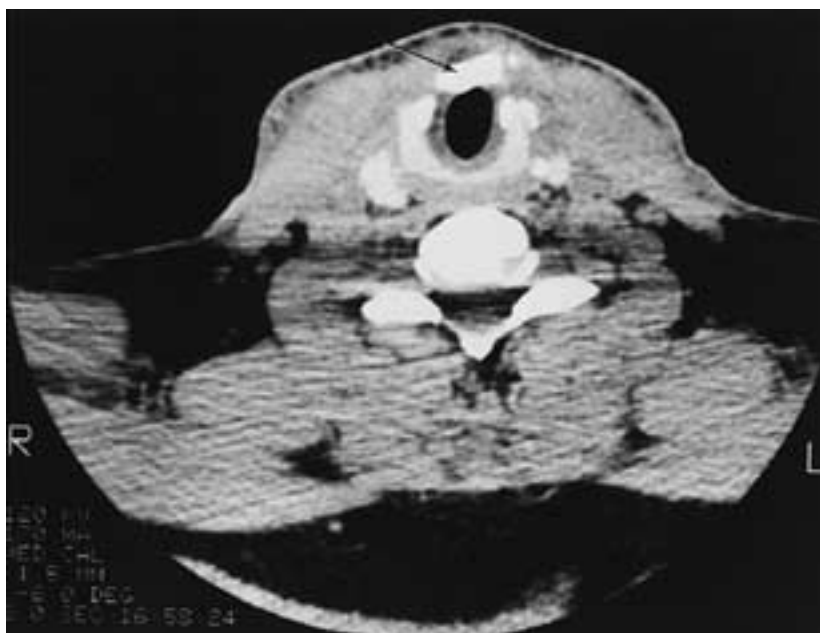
Axial CT, cartilaginous graft (*arrow*) placed in the anterior arch of the cricoid to support and maintain the lumen of the airway.
